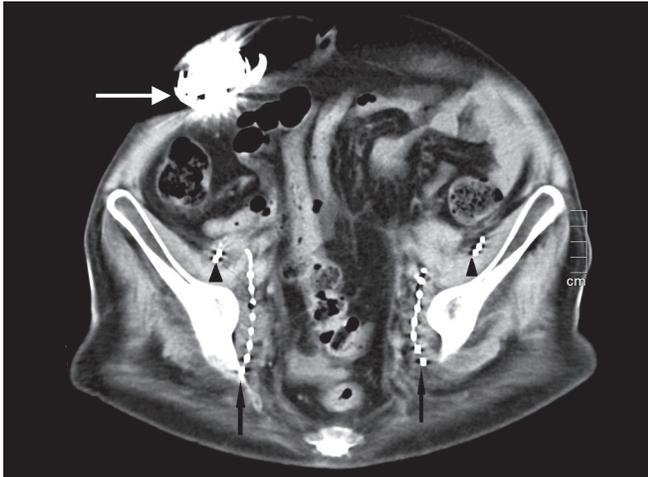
CT scan showing the correct placement of IPG, femoral lead, and sciatic lead
